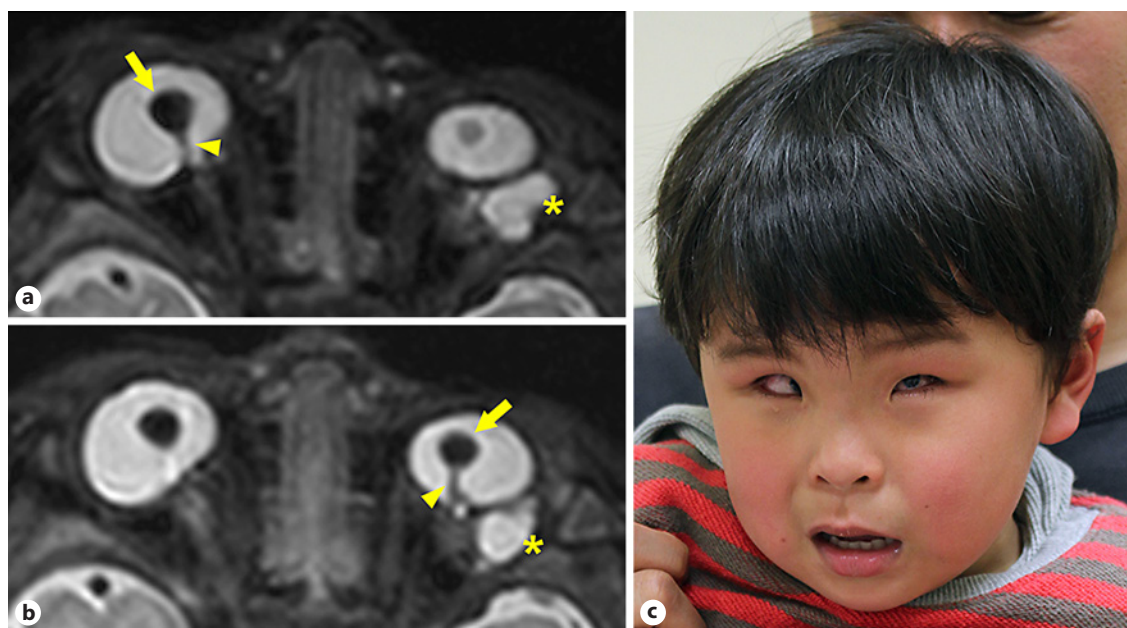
MRI images of the eyes and a photograph of the patient. a, b MRI of the patient's eyes at the age of 1 month show bilateral PHPV with microphthalmia and colobomatous cysts. Axial view of T2-weighted image focused on the right (a) and left eye (b). Both eyeballs are small and irregularly shaped. Dysplastic lenses (arrows) are located in the center of vitreous chambers and funicular structures (arrow heads) extend to the posterior wall of eyeballs. Multiple cystic structures (asterisks) were found behind eyeballs. c Photograph of the patient at the age of 3 years and 4 months showing straight eyebrows, epicanthal folds, strabismus, and a prominent philtrum.
